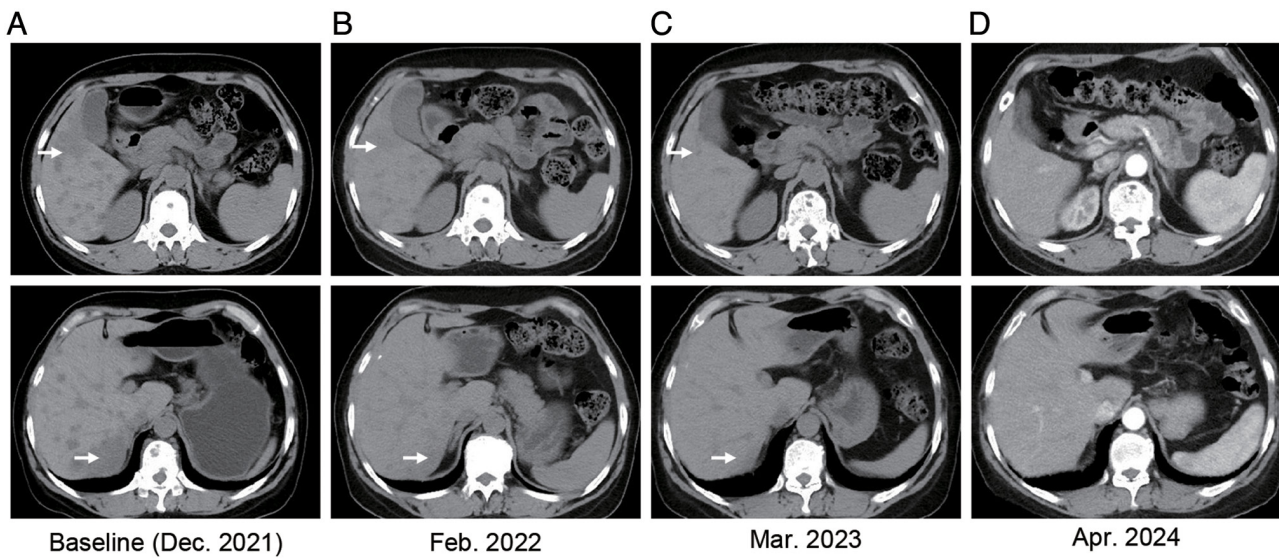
Changes of liver metastases in CT scanning images during the treatment of abemaciclib plus letrozole. Arrows indicate two main areas of liver metastases at different scan levels (upper and lower panels). (A) The baseline of liver metastases at the beginning of abemaciclib and letrozole (December 2021). (B) After two cycles of treatments, both the number and volume of multiple hepatic metastases exhibited marked decreases (February 2022). (C) Liver metastasis in March 2023. (D) Liver metastasis in April 2024.
